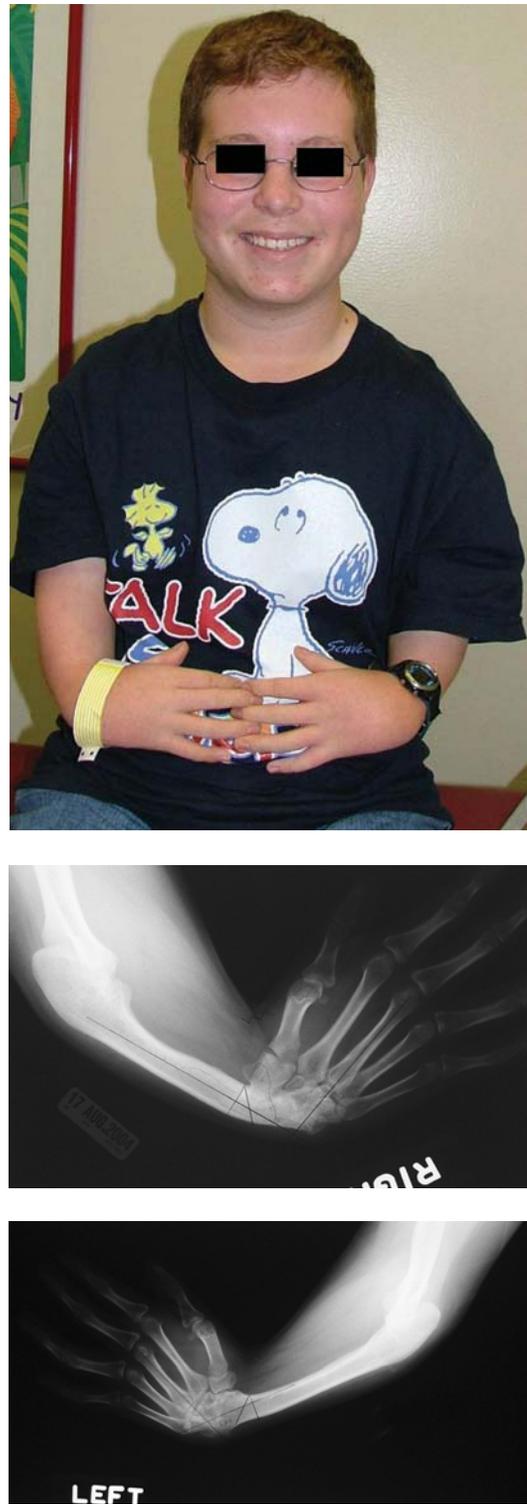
A 14-year-old boy with TAR syndrome showing similar clinical and radiographic features.
